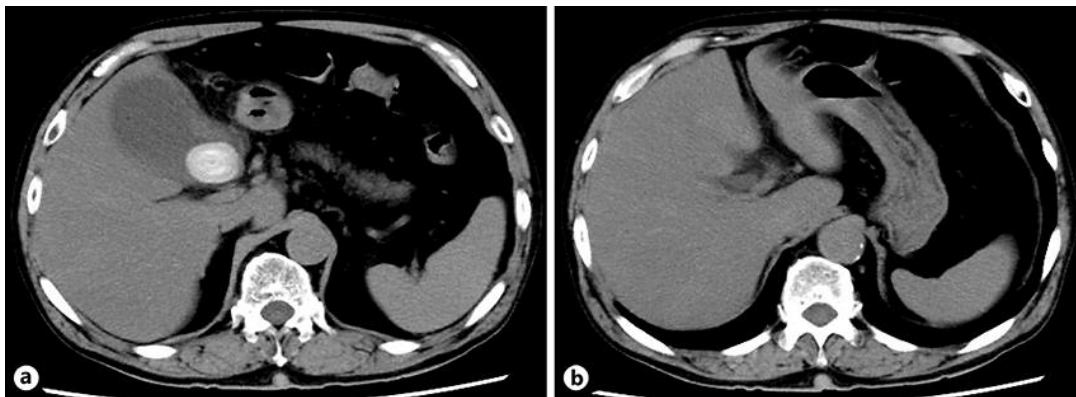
Abdominal computed tomography examination. a Acute cholecystitis with a gallstone. b No gastric wall thickening or perigastric lymphadenopathy was seen.
